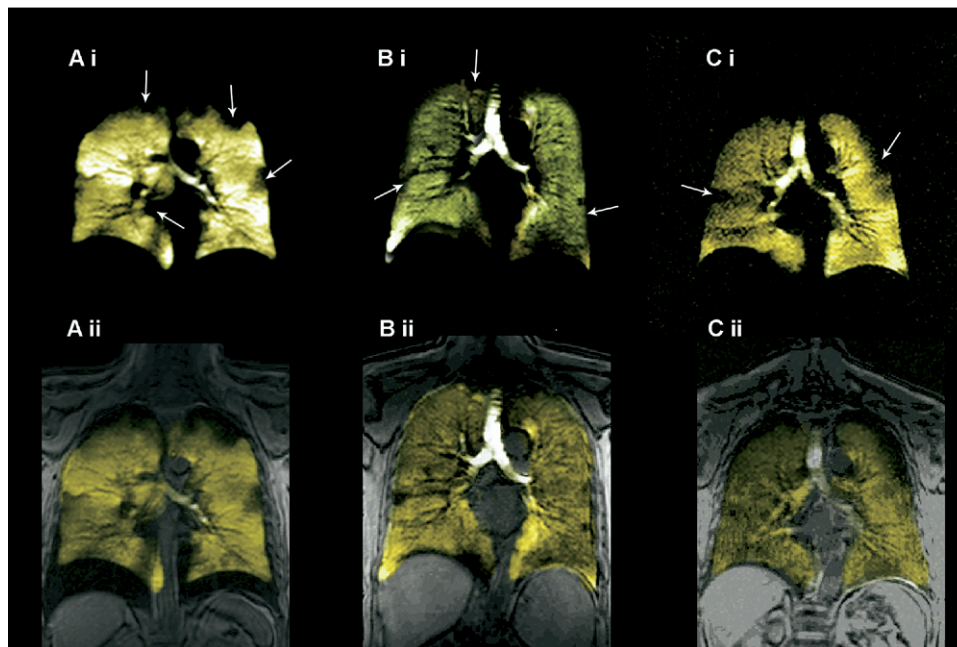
Elderly healthy volunteers ^3He magnetic resonance imaging. (a) Subject 7-1004 70-year-old female, forced expiratory volume in 1 second (FEV_1) = 149% predicted, $\text{FEV}_1/\text{forced vital capacity (FVC)}$ = 75% (i) ^3He image (ii) overlay of ^3He image with ^1H thorax image. (b) Subject 7-1007 73-year-old male, FEV_1 = 104% predicted, FEV_1/FVC = 84%. (i) ^3He image (ii) overlay of ^3He image with ^1H thorax image. (c) Subject 7-1008 74-year-old male, FEV_1 = 91% predicted, FEV_1/FVC = 79% (i) ^3He image (ii) overlay of ^3He image with ^1H thorax image.
